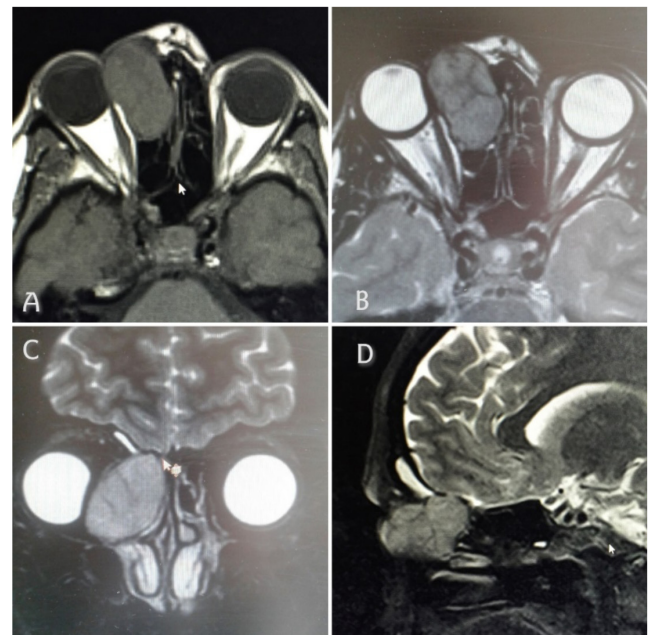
A) A hypodense mass (isodense to soft tissue) was detected on T1-weighted magnetic resonance imaging (MRI). B) In the axial section of the MRI, a septated mass originating from the extraconal space and causing destruction of the bones was observed. C) The coronal section of the MRI showed that the mass reached the ethmoid cells and pushed the medial orbital wall. D) The sagittal section of the MRI showed a 3.5-mm defect in the fovea ethmoidalis and the mass extending posteriorly and approaching the brain
